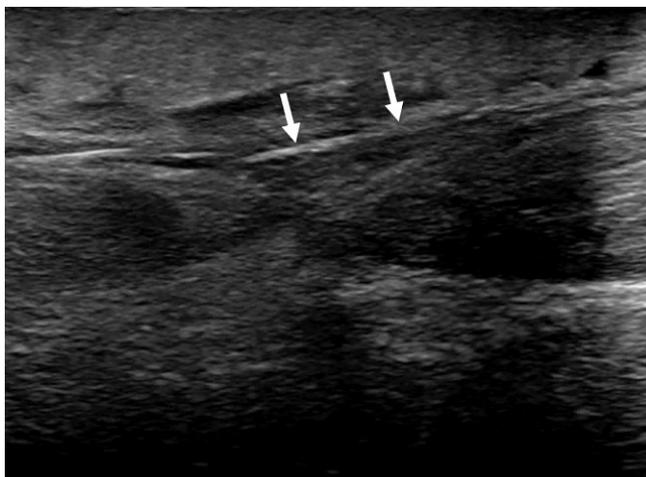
◀ Ultrasound image in the longitudinal plane delineating the margins of the gap 15 days post-surgery clearly showing the suture threads (*arrows*) used to approximate the tendon stumps without artifacts
